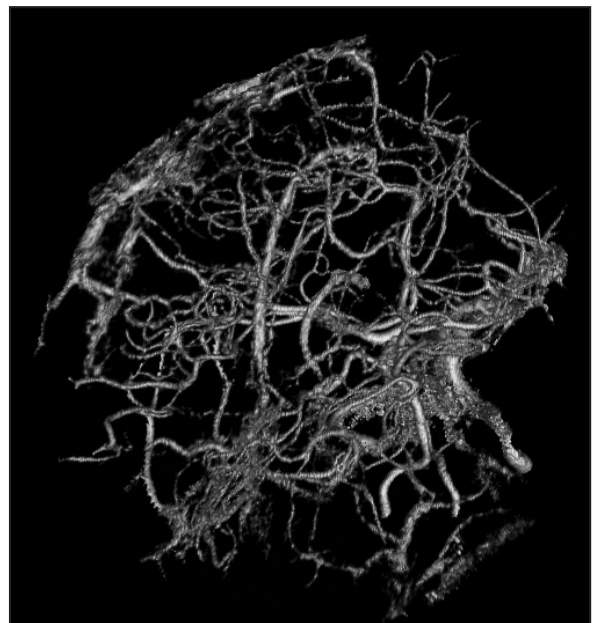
Angio-CT: the superior longitudinal, straight and transverse sinuses do not stand out.
